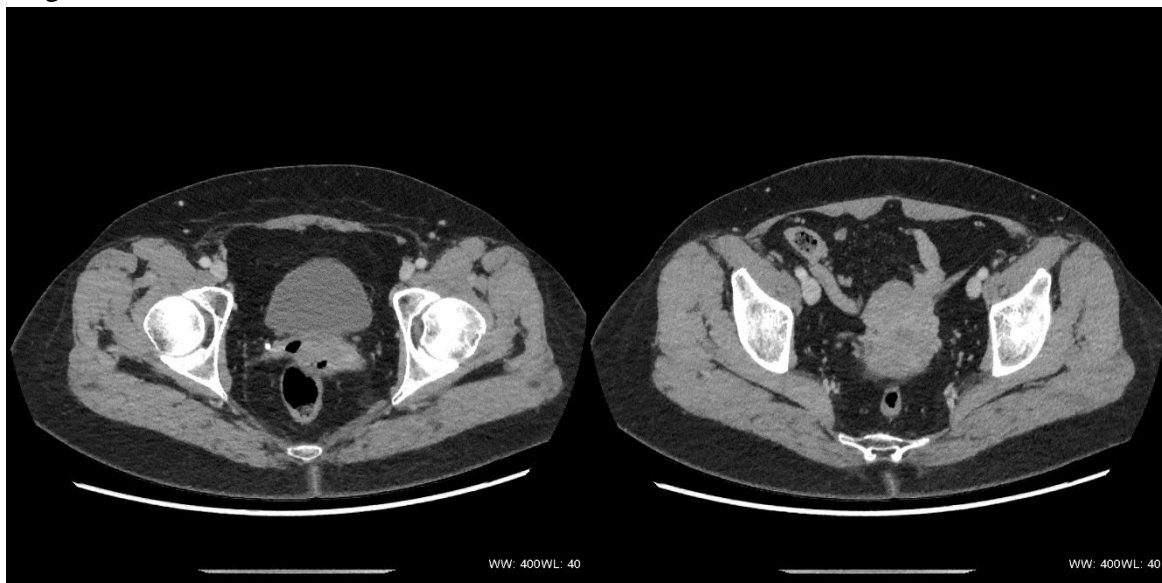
CT scans from January 2022
